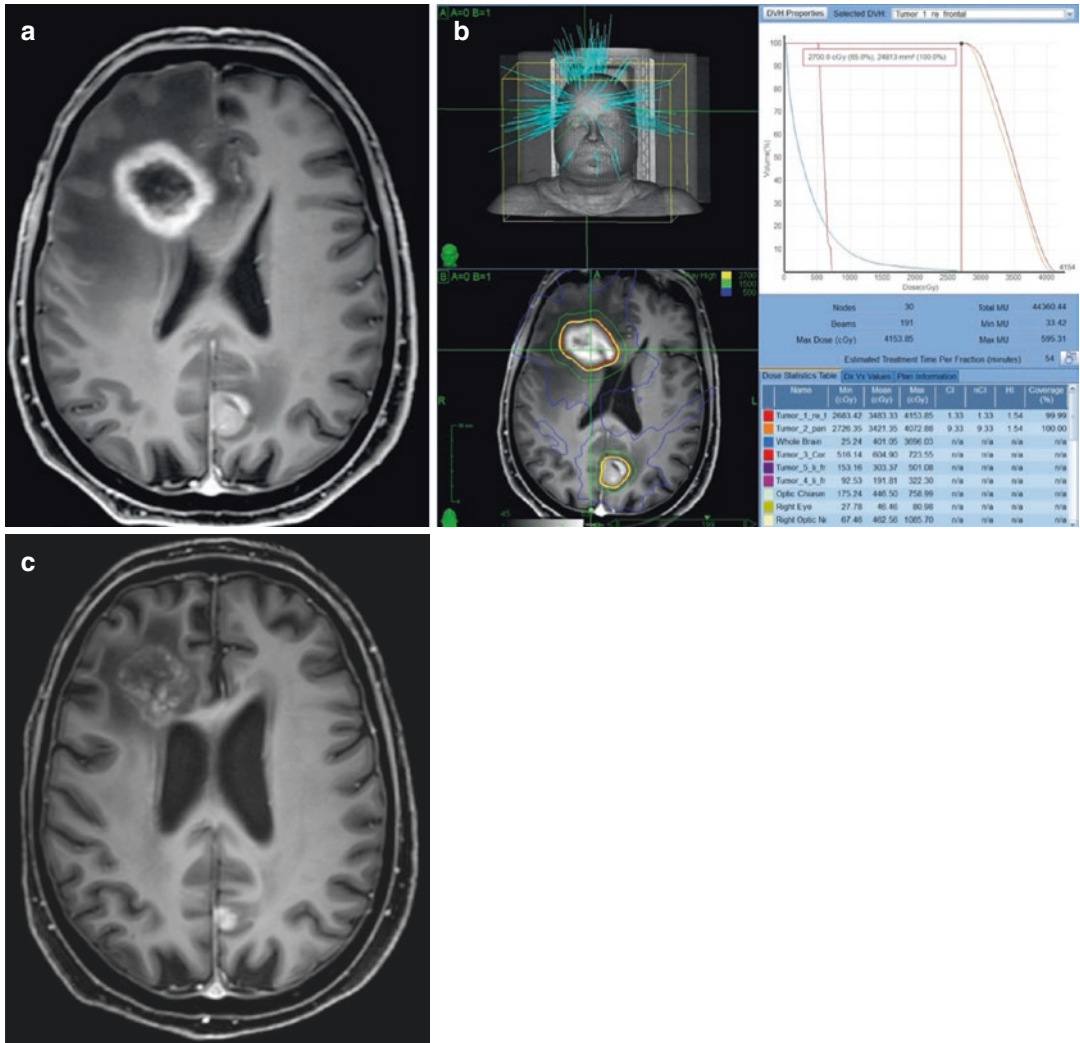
(a) MRI scan from November 2016 from a 65-year-old female diagnosed with small cell lung cancer in March 2015. Besides multimodal systemic treatment, she received prophylactic whole brain radiation therapy (30 Gy; ten fractions) from August to September 2015. (b) As salvage treatment she received hypo-fractionated CyberKnife SRS with a dose of 27 Gy in three fractions for two brain metastases [right frontal (volume = 24.8 cm³); left parietal (volume = 3.5 cm³)] since a
